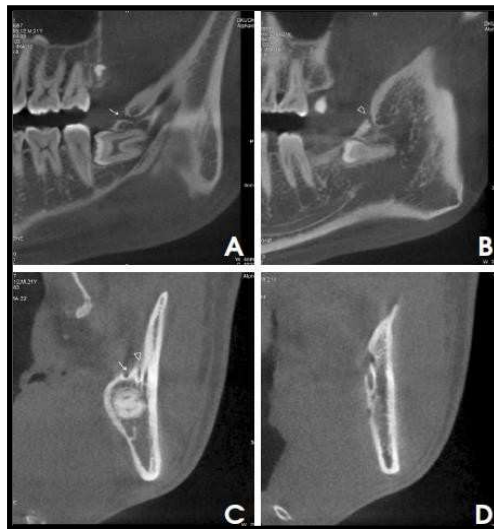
CBCT images show canal type 5E (trifid canal type: two accessory canals of the retromolar canal type (A-C) with two mandibular foramina (D))
